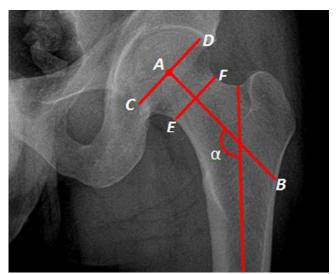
The method of measurement of radiographic parameters. femoral neck length: Length between lateral cortex in proximal femur (B) and center of femoral head along femoral neck axis (A); Femoral head diameter: Femoral head diameter drawn from center of femoral head (Line C-D); Femoral neck diameter: Longest femoral neck diameter (Line E-F); Femoral neck offset: the ratio of femoral head to femoral neck; Neck-shaft angle (α): the angle between femoral shaft axis and femoral neck axis.
